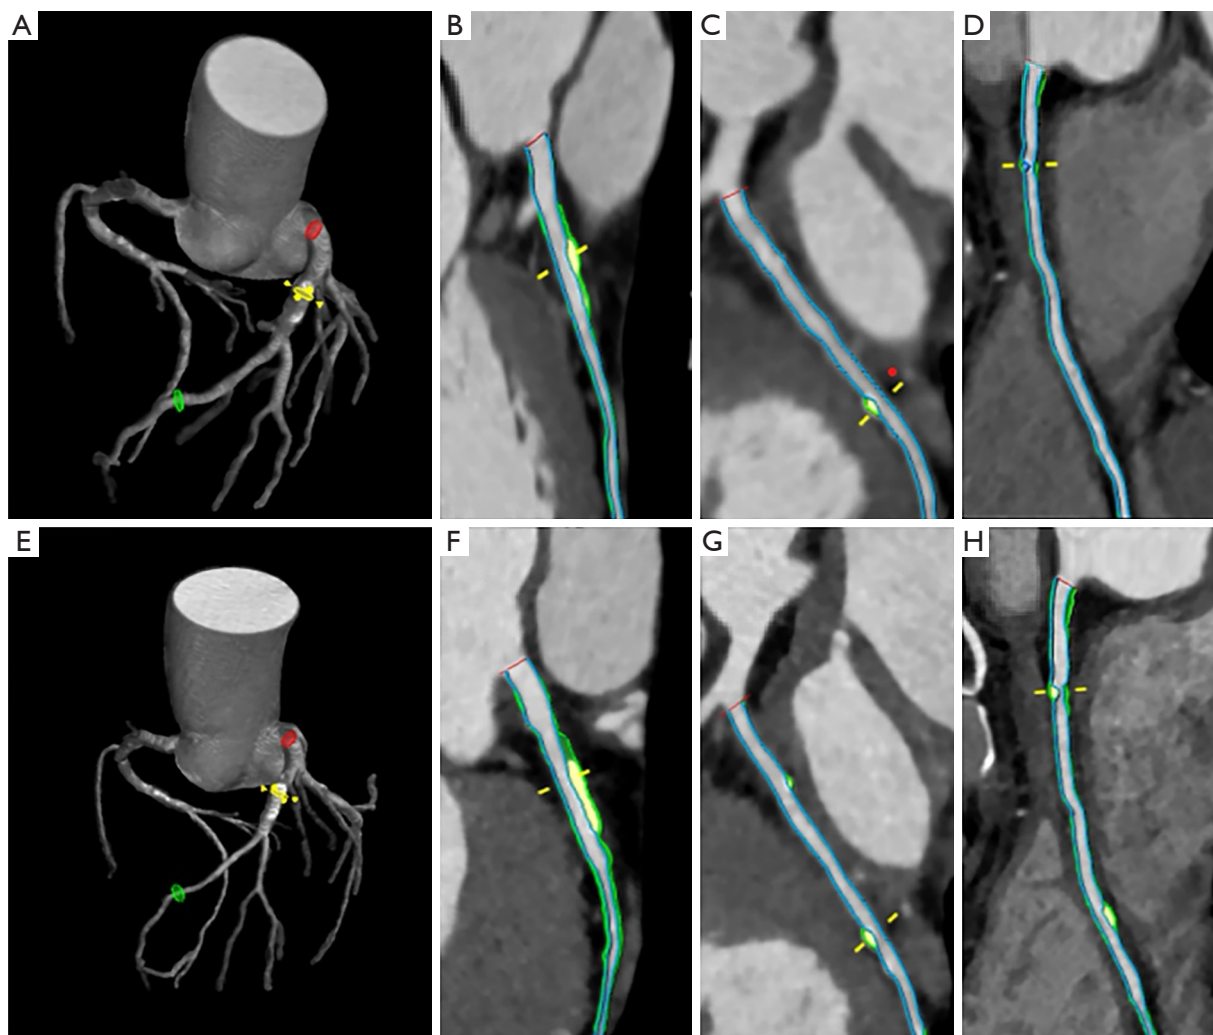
Baseline and follow-up CCTA reconstructed images of a 71-year-old man with MACE. Baseline CCTA (A-D) showed mixed plaques in the left anterior descending, left circumflex, and right coronary arteries. The total, noncalcified, low attenuation, fibro-fatty, fibrous, and calcified PB were 36.4%, 12.0%, 0.0%, 1.5%, 10.5%, and 24.4% respectively. Follow-up CCTA (E-H) showed the progression of the total PB and reduction of PCPB. The total, noncalcified, low attenuation, fibro-fatty, fibrous, and calcified PB were 62.0%, 32.0%, 1.0%, 15.8%, 15.2%, and 30.0%, respectively. The area outlined by the blue line is the coronary artery lumen, and the area between the green and blue lines is the coronary artery plaque. Yellow and white represent calcification and green represents noncalcification. CCTA, coronary computed tomographic angiography; MACE, major adverse cardiovascular event; PB, plaque burden; PCPB, percent calcified plaque burden.
